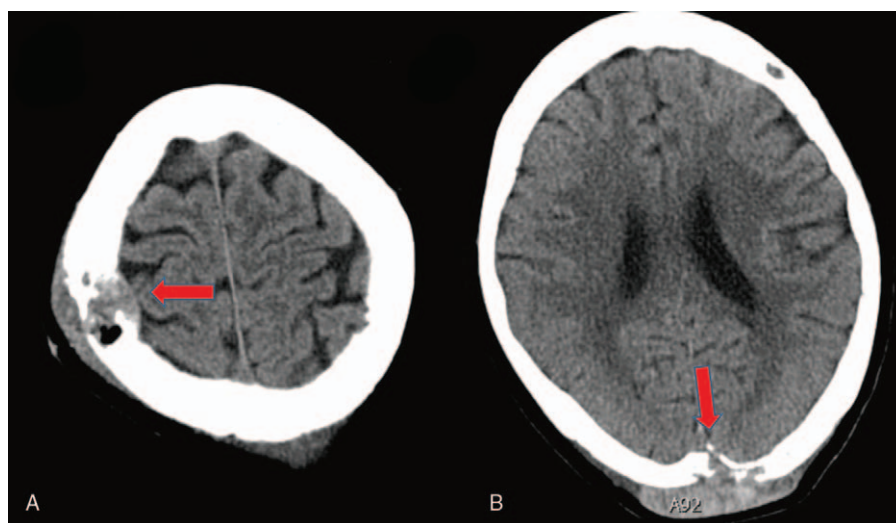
(A, B) Unenhanced head CT revealed diffuse skull destruction, decreased bone density, especially at right parietal and posterior area, soft tissue mass, and intruded skull.
